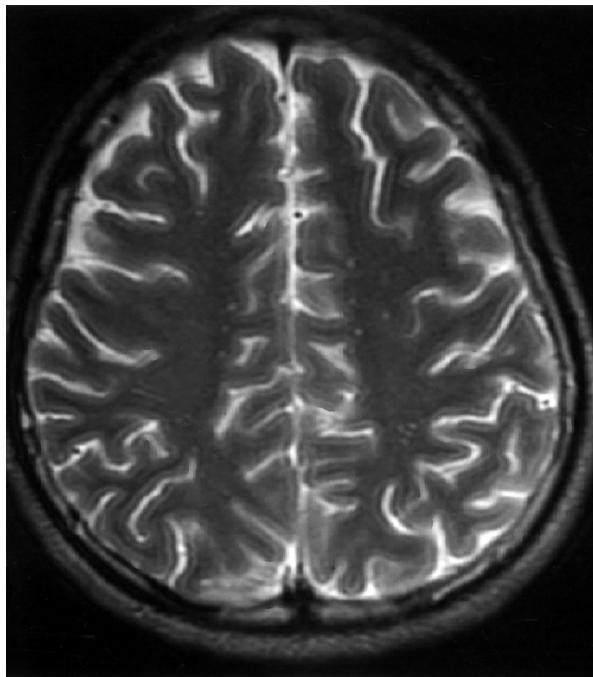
Brain MRI after seizure revealing multiple hyperintense dots on the T2-weighted image.
